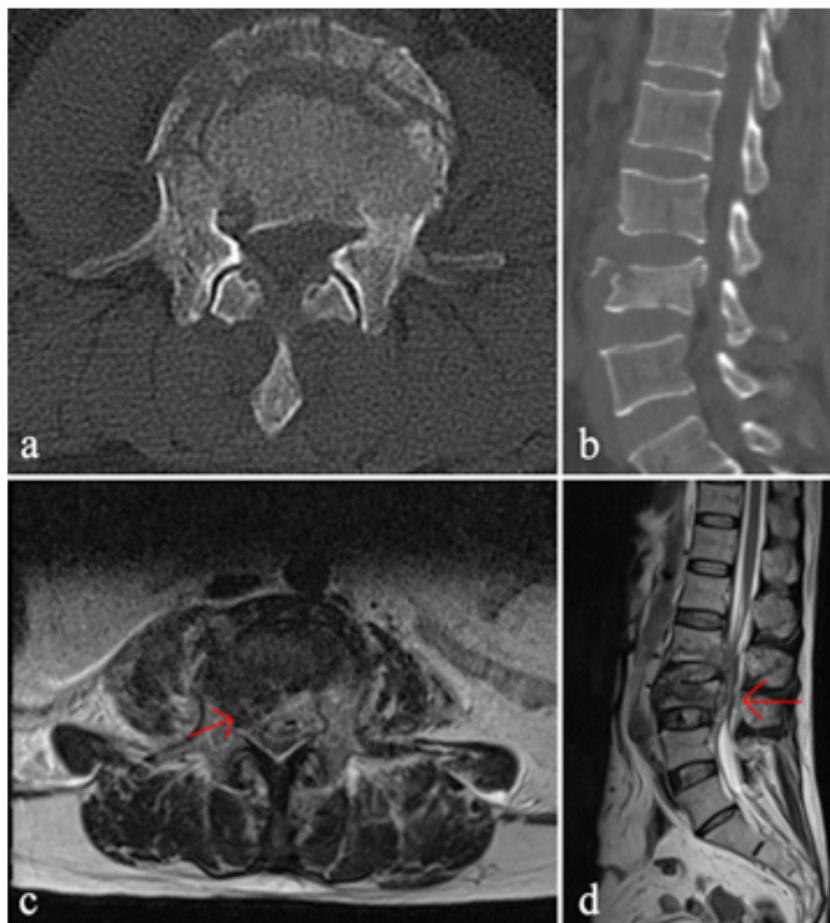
Preoperative CT and MRI imaging examinations. (a-b) Preoperative CT and MRI showed L2, L3 burst fracture, L3 secondary spinal stenosis, cauda equina damage (red arrows represent spinal nerve damage).
